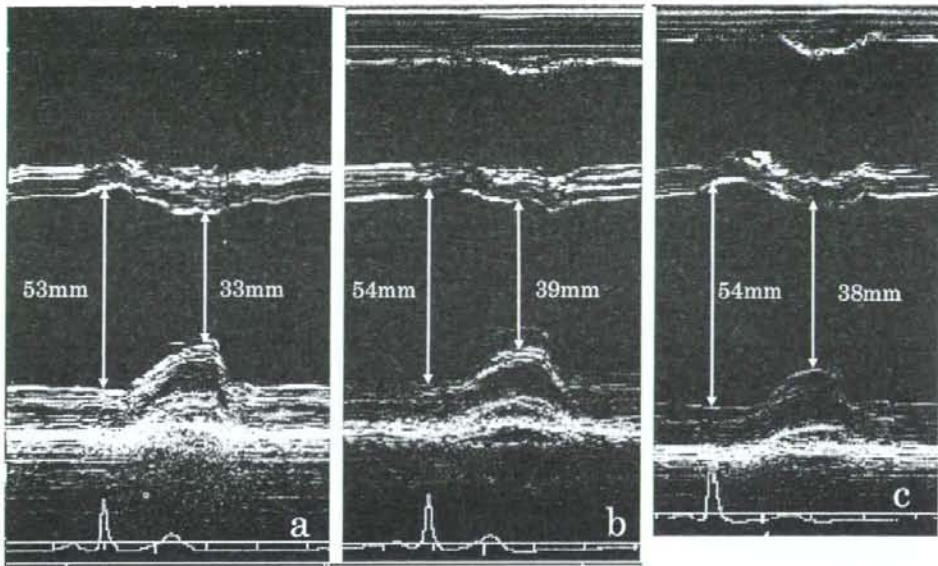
M-mode echocardiographic changes in a woman with dilated cardiomyopathy (DCM) during her pregnancy and after delivery
